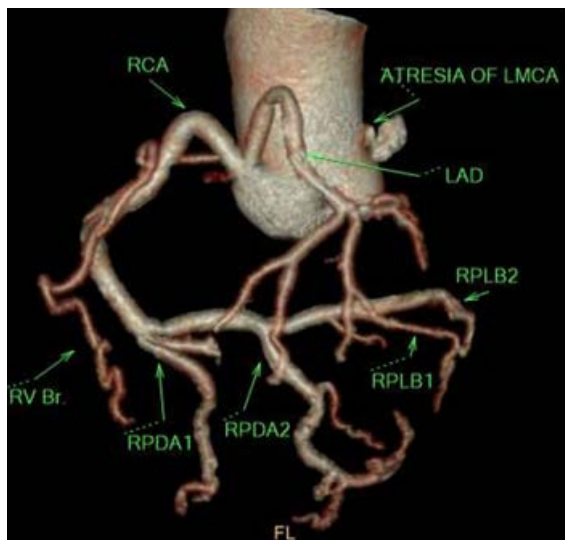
Coronary computed tomography angiography (CCTA) identified the anomaly single coronary ostium
